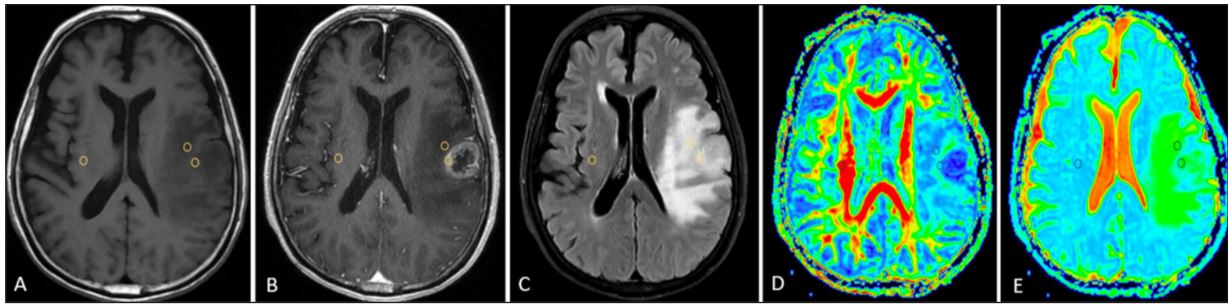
A 71-year-old man with a right frontal GBM. Pre-contrast T1-weighted T1W (A), post-contrast T1W (B), and axial fluid-attenuated inversion recovery (C) images show a heterogeneous tumor with central necrosis, ring enhancement, and peritumoral infiltration. Three regions of interest were placed in a solid tumor component, the peritumoral region, and the opposite normal white matter and measured using the FA (D) and MD maps (E).
